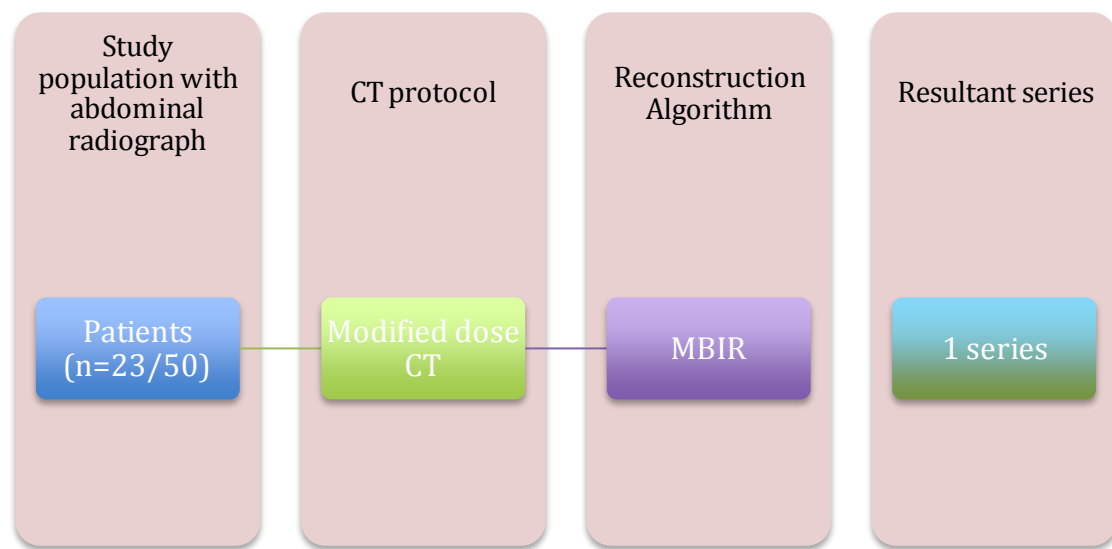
summary of the study population. Twenty-three of fifty patients who underwent the split dose CT protocol had a contemporaneous plain abdominal radiograph.
